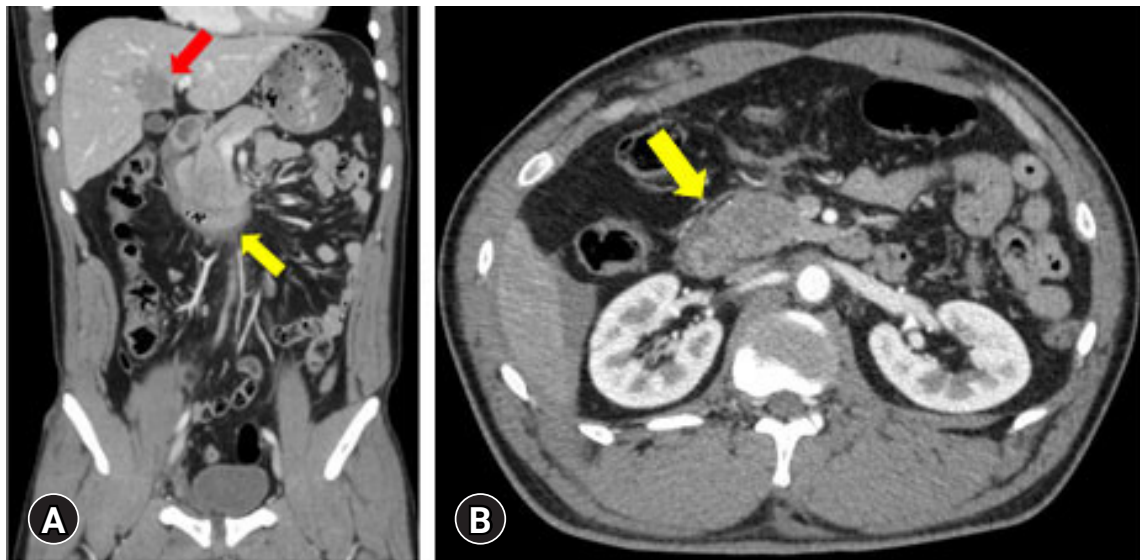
Initial abdominal-pelvic computed tomography. (A) Coronal view shows liver laceration (red arrow) and pancreas head injury (yellow arrow). (B) Axial view shows the pancreas head injury (arrow).
